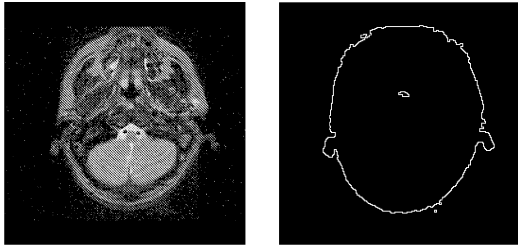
MRI slice and its extracted 2-D surface.
